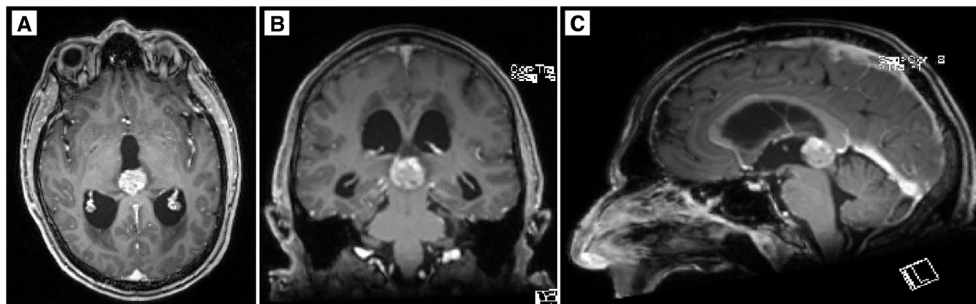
Radiographic characteristics of the pineal metastasis. A) Axial, B) coronal, and C) sagittal magnetic resonance images of the brain show a 2.2 cm, heterogeneously enhancing mass isolated to the pineal region in the brain.
